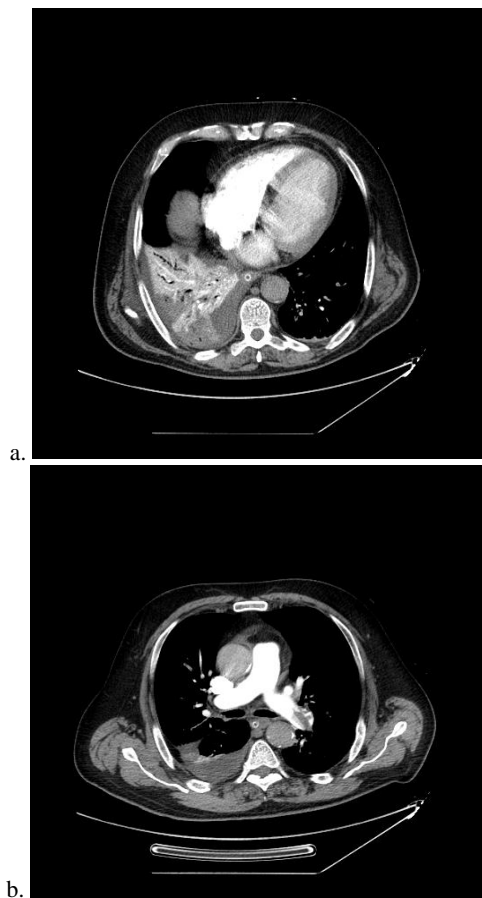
10.05.2020. Computed tomography, axial section. Vascular window. Incision at the level of basal segments.
